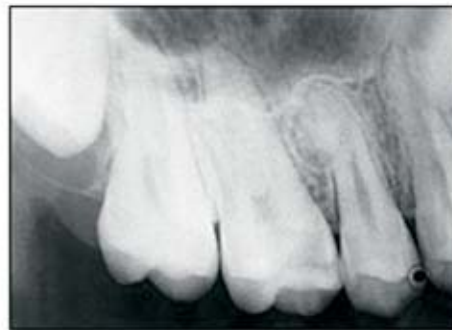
Periapical radiograph showing the presence of a supernumerary premolar tooth and a supernumerary molar tooth in right maxilla.
